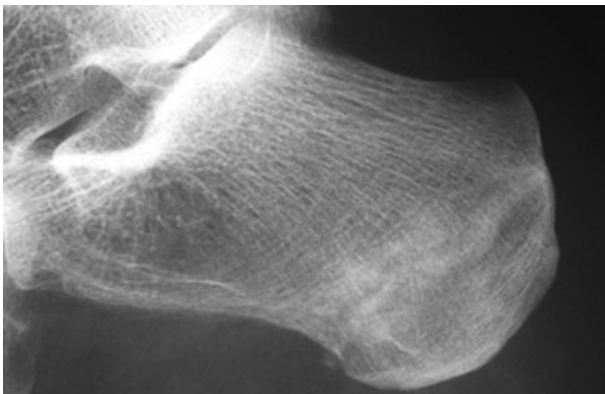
Radiograph demonstrating calcaneal stress fracture.
